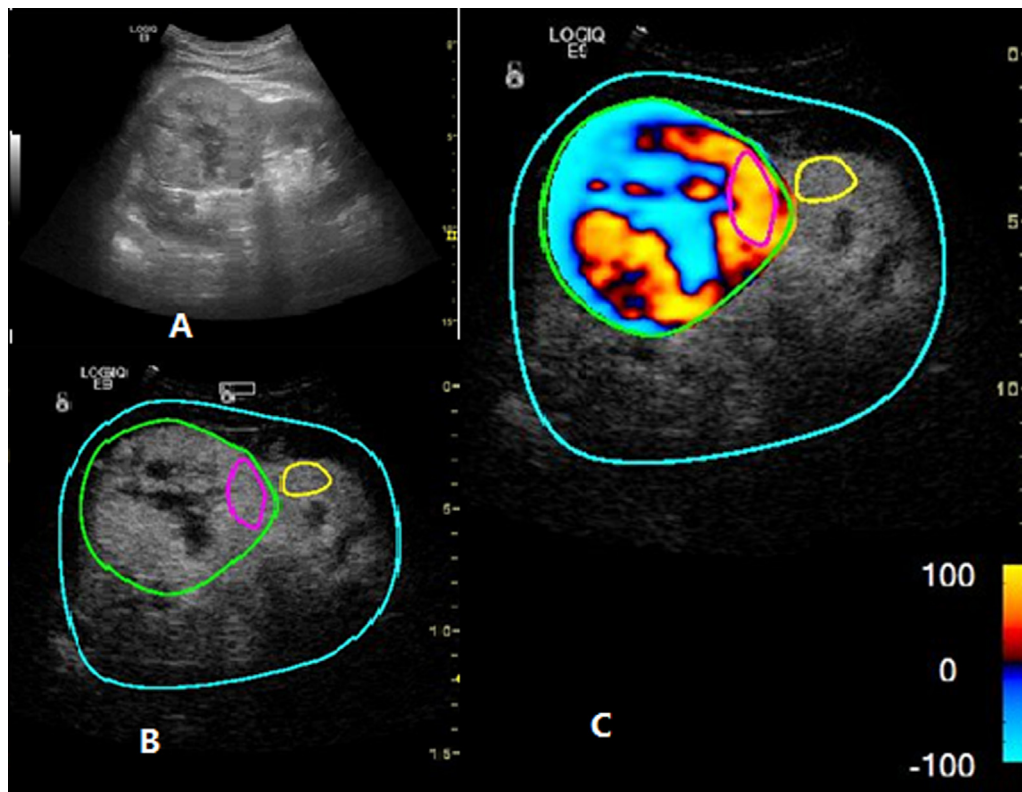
The definitions of region of interest (ROI) A heterogeneously hyper-echoic lesion on baseline ultrasound (A), The lesion showed heterogeneously hyper-enhancement at peak on CEUS (B). The delimitation ROI (turquoise) included the lesion and normal renal parenchyma, the ROI_{tumor} (green) outlined the whole lesion tissue and the ROI_{refer} (yellow) outlined the healthy normal renal cortex next to the lesion. ROI_{max} (magenta) was drawn based on the parametric color map (C) and it kept at the same depth as ROI_{refer}.
